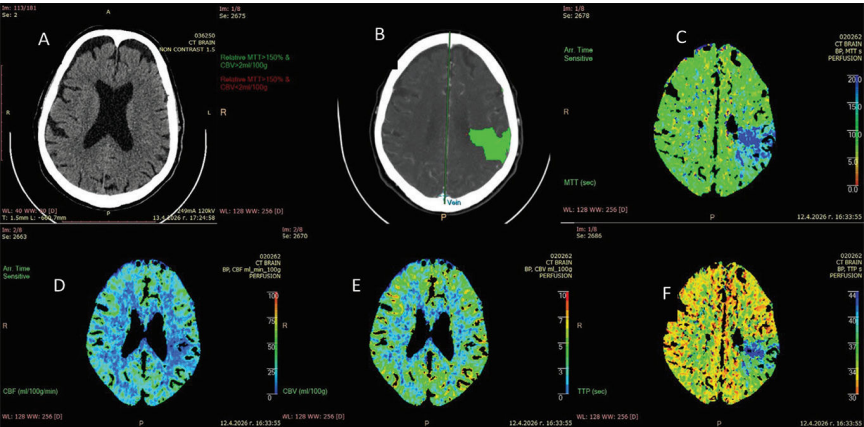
Non-contrast CT and perfusion maps (MTT, TTP, CBV and CBF) demonstrating a focal area of hypoperfusion in the left M5 segment, characterized by prolonged mean transit time and time to peak, with preserved cerebral blood volume, suggestive of ischemic penumbra
